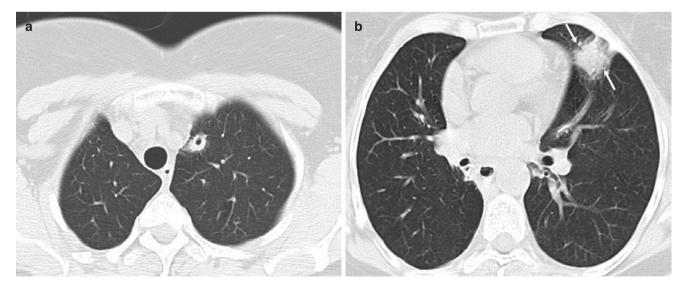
A 57-year-old woman with granulomatosis with polyangiitis. (a-c) Axial CT images show cavitary nodules in the left upper and left lower lobe with a nodule with "halo" sign (arrows) in lingula
